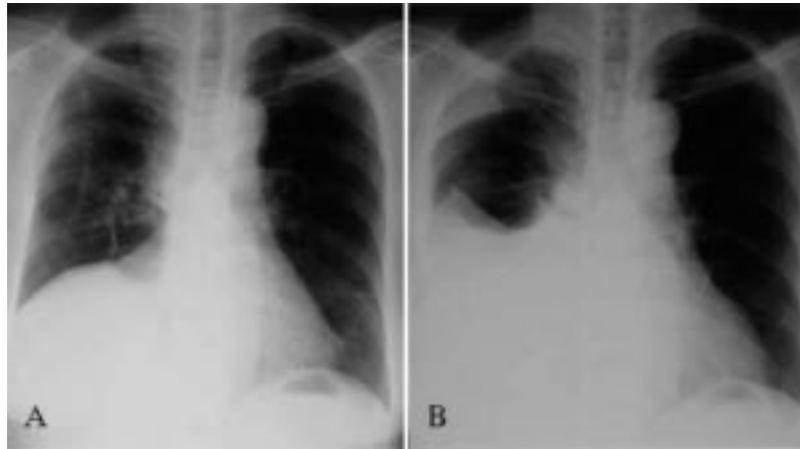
(A) Chest roentgenogram taken on postoperative day 18, and (B) the chest roentgenogram leading to a diagnosis of postoperative chylothorax.
